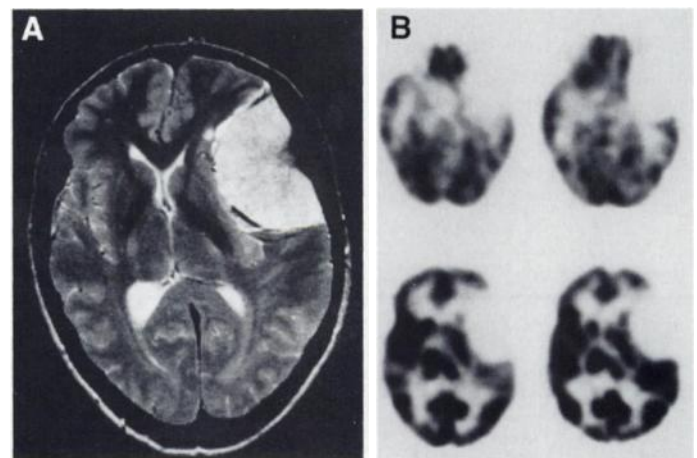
Corresponding MR (A) and PET (B) scans of a patient with a large grade 1 meningioma of the left lateral sphenoid. The tumor is seen as a defect area with homogeneous low FDG uptake compared to gray matter (SUV = 3.1; TGR = 0.36).
